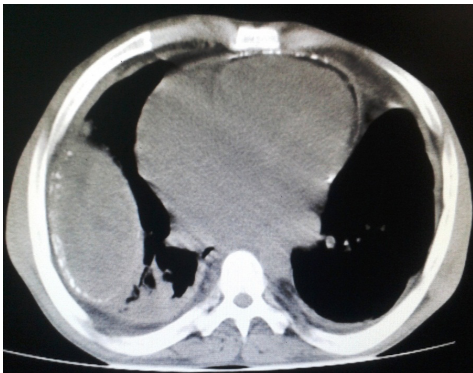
CT shows right side loculated pleural effusion with calcifications , pericardial calcifications.
